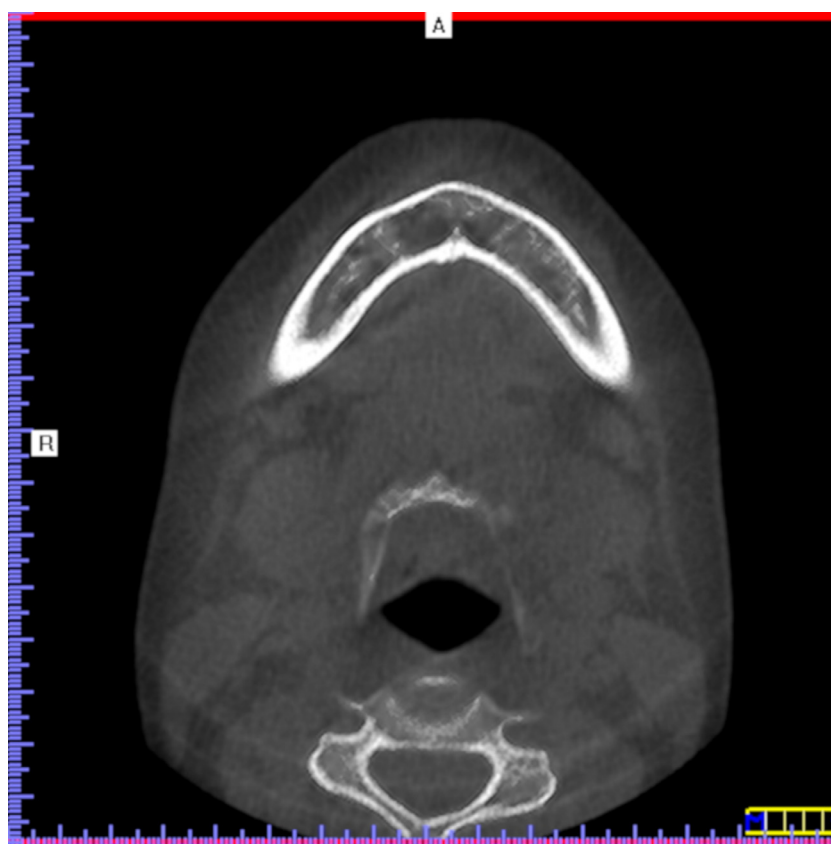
Axial view of the cone beam computed tomography (CBCT) image suggesting no apparent interruptions to the buccal and lingual cortices surrounding the radiolucency.
